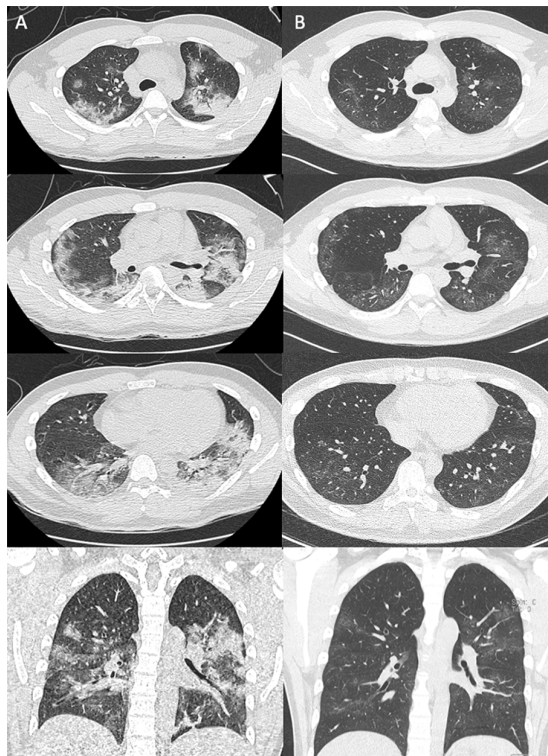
(A) HRCT on day 14 after admission demonstrated multifocal peripheral ground-glass opacities and consolidation in bilateral lungs with reversed halo sign or “atoll” sign. (B) HRCT at 2 weeks follow-up after pulse methylprednisolone revealed significant improvement of multifocal consolidation. Only minimal ground-glass opacity remained.
